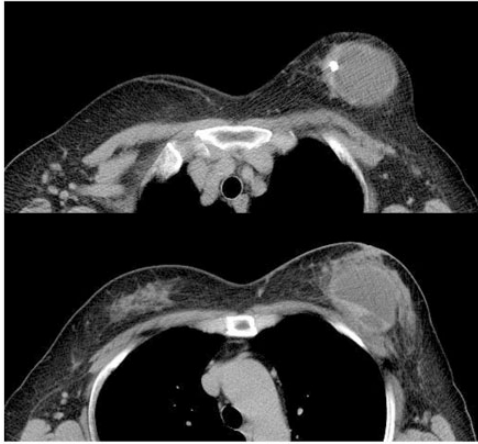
Computed tomography revealed a well-defined cyst behind the gland in the left breast with a diameter of 7.6 cm, compressing the anterior aspect of the mammary gland. The thickness of the cyst wall was 0.2 to 1.0 cm, with popcorn-like calcification in the left wall. Septa divided the cystic spaces. The cyst cavity had a homogeneous density, and the computed tomography value was -2 to 6 HU.
